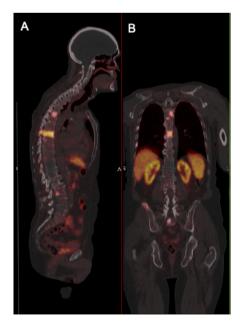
87-year-old patient, previous radical prostatectomy, Gleason grade 5, PSA before PET 2.64ng/ml. ¹⁸F-1007-PSMA fused sagittal (A) and coronal (B) images demonstrating skeletal metastases in the thoracic and lumbar spine, sacrum and pelvis.
